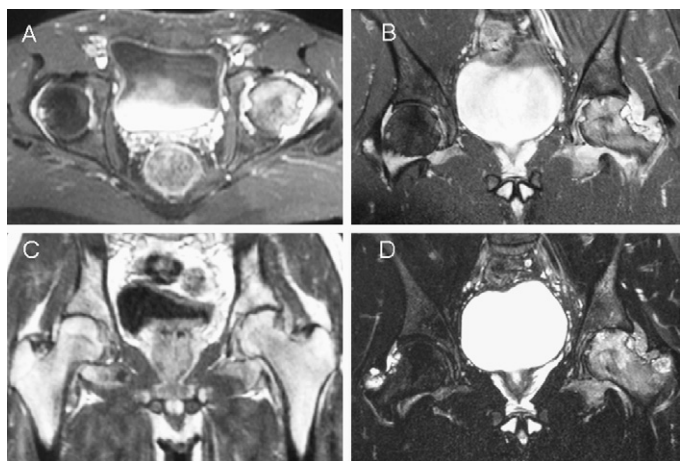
MRI of the hips. Gadolinium-enhanced axial (A) and frontal (B, C) T1-weighted, and frontal T2-weighted (D) sequences. Note the rapid gadolinium enhancement of bilateral synovial thickening (pannus) and intra-articular joint effusion on T1-weighted sequences (A, B versus C), with high signal intensity on T2-weighted sequences, indicative of an inflammatory process, associated with numerous subchondral erosions on both femoral heads and acetabula (C and D).
